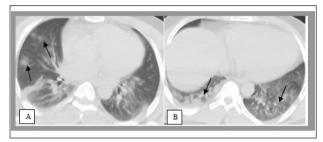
Axial chest CT images (A,B) show nodular and patch GGOs and consolidations (arrows).
